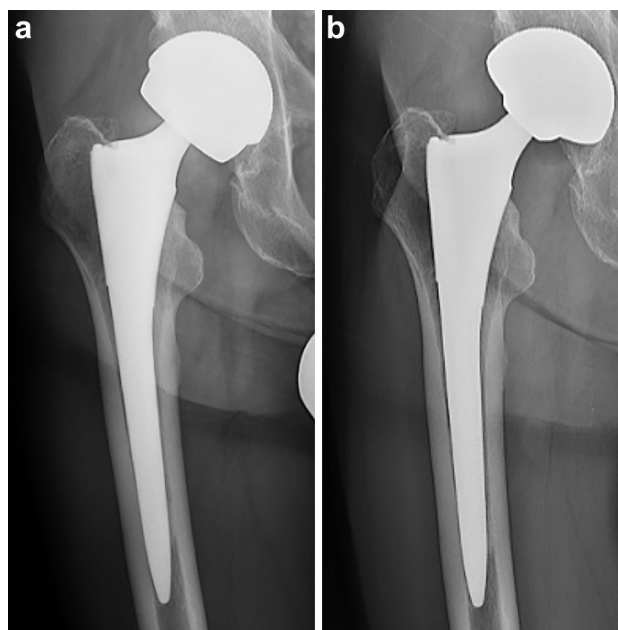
a Preoperative AP X-ray of a MoM THA. b AP X-ray after off-label revision using a dual mobility liner in the pre-existing shell
